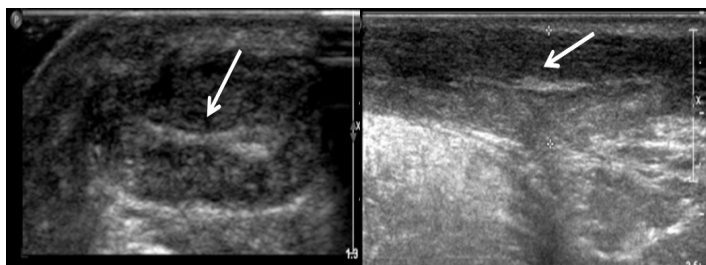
Ultrasound of the Achilles tendon. Thickened Achilles tendon with a longitudinally oriented focus of increased echogenicity (arrows) reflected intra-tendinous persistent suture. Resolution of encysted material surrounding the sutures when compared to previous ultrasound.
